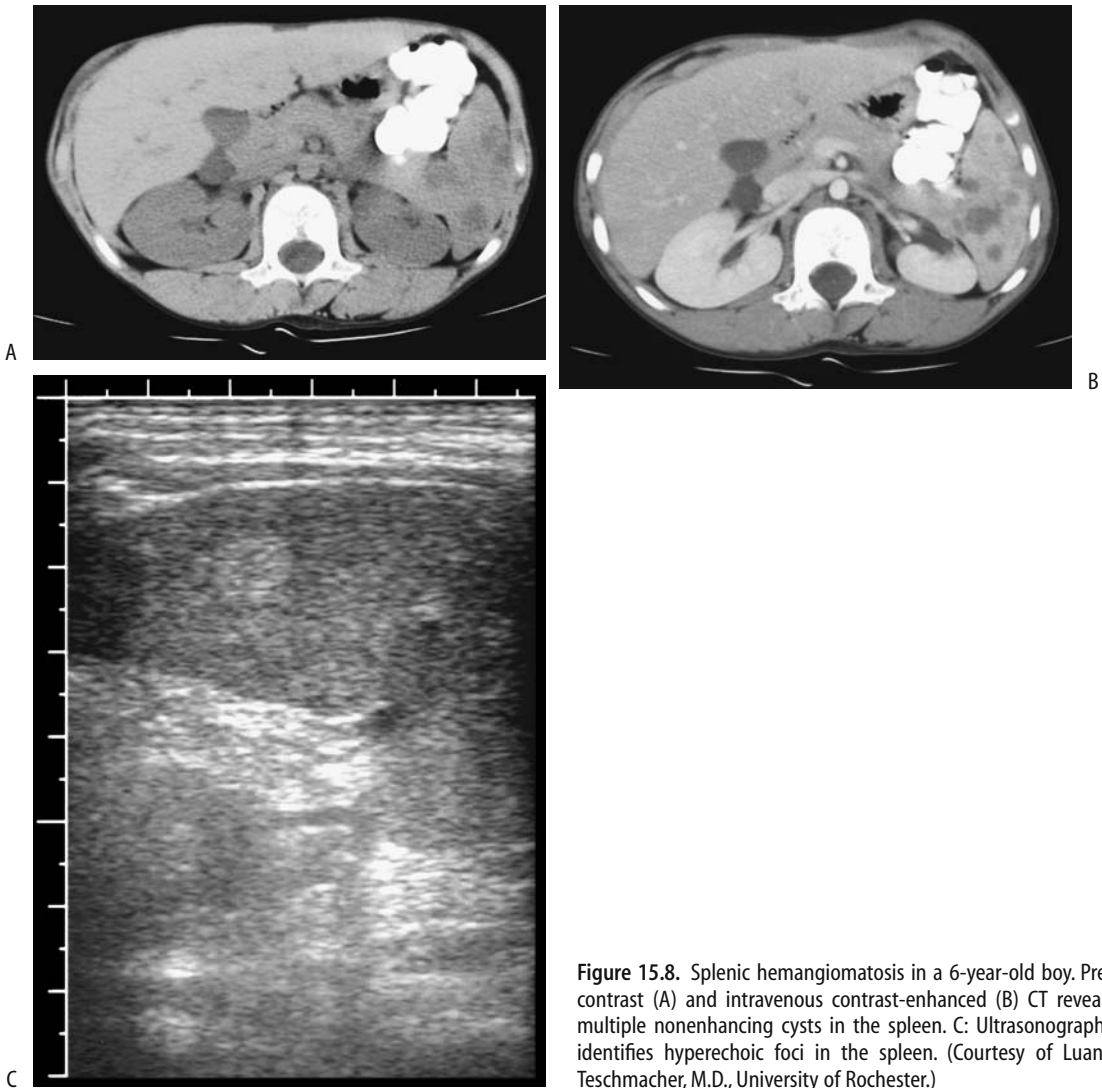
Splenic hemangiomatosis in a 6-year-old boy. Pre-contrast (A) and intravenous contrast-enhanced (B) CT reveals multiple nonenhancing cysts in the spleen. C: Ultrasonography identifies hyperechoic foci in the spleen. (Courtesy of Luann Teschmacher, M.D., University of Rochester.)
